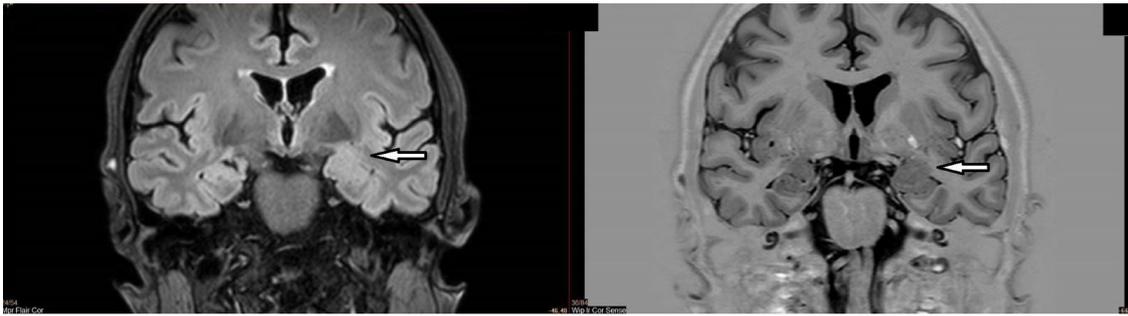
Cranial MRI displaying increased volume of the left amygdala
